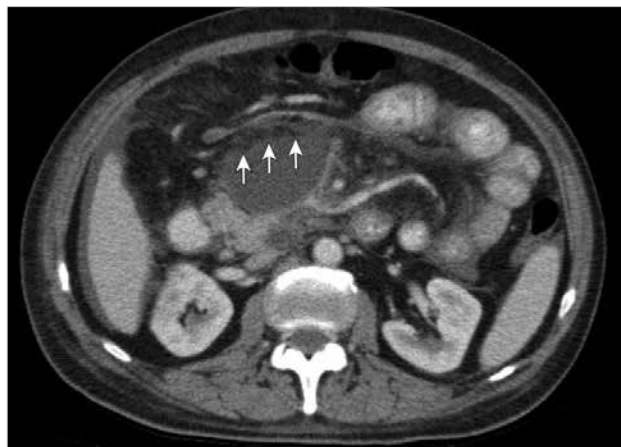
Computed tomography image of the irregular, extensive, hypodense retroperitoneal fluid collection, with dimensions of $9 \times 7 \times 6$ cm also revealing a thin fat-fluid level marked by the arrows
